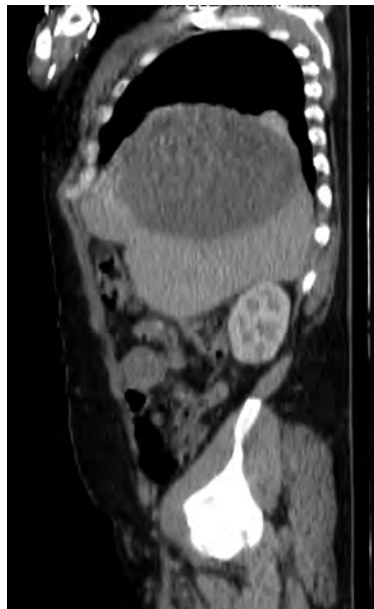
Paramedial sagittal section of thorax and abdomen computed tomography scan with a hepatic cystic lesion displacing segments VII and VIII and diaphragm into intrathoracic region.*
